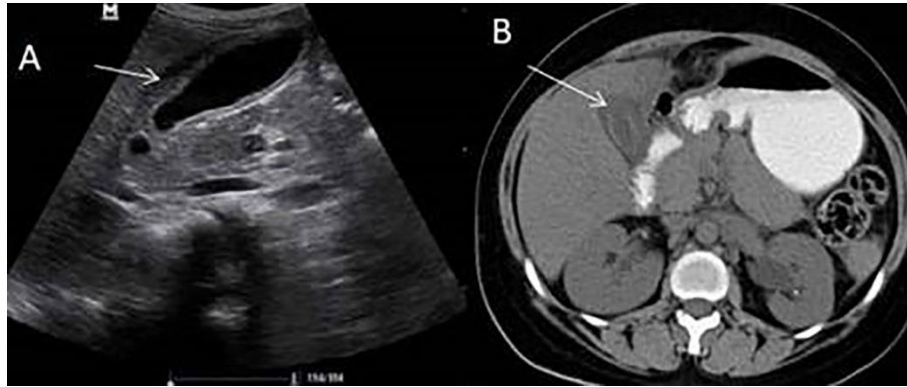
(A) Ultrasound imaging of the abdomen: shows diffuse wall thickening (9 mm) of gall bladder with septation. No calculi. Gall bladder (GB) is not abnormally distended. There is minimal pericholecystic collection. Features suggest acute acalculous cholecystitis. (B) Non contrast CT of liver support acute cholecystitis findings [no GB calculus, GB wall thickening of 9mm, subserosal halo sign (intramural lucency caused by edema) and pericholecystic fluid collection, denoted by arrow.
